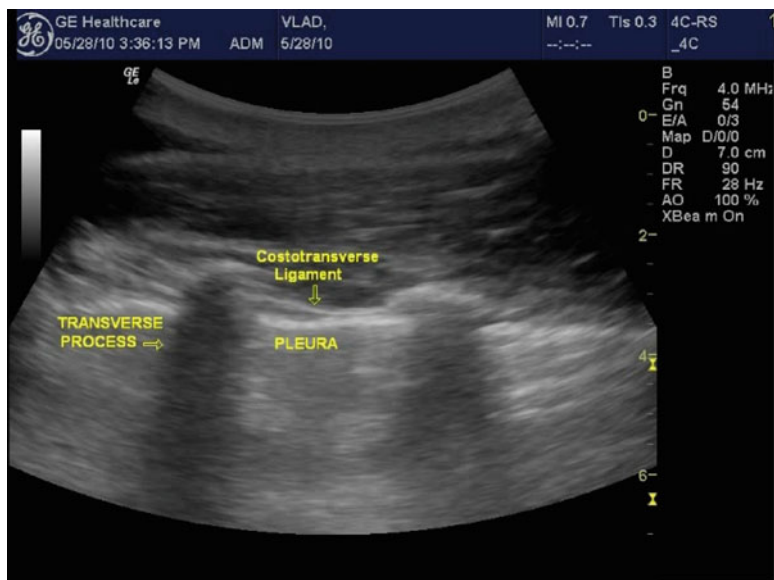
The paramechanical ultrasound view of the paravertebral space
